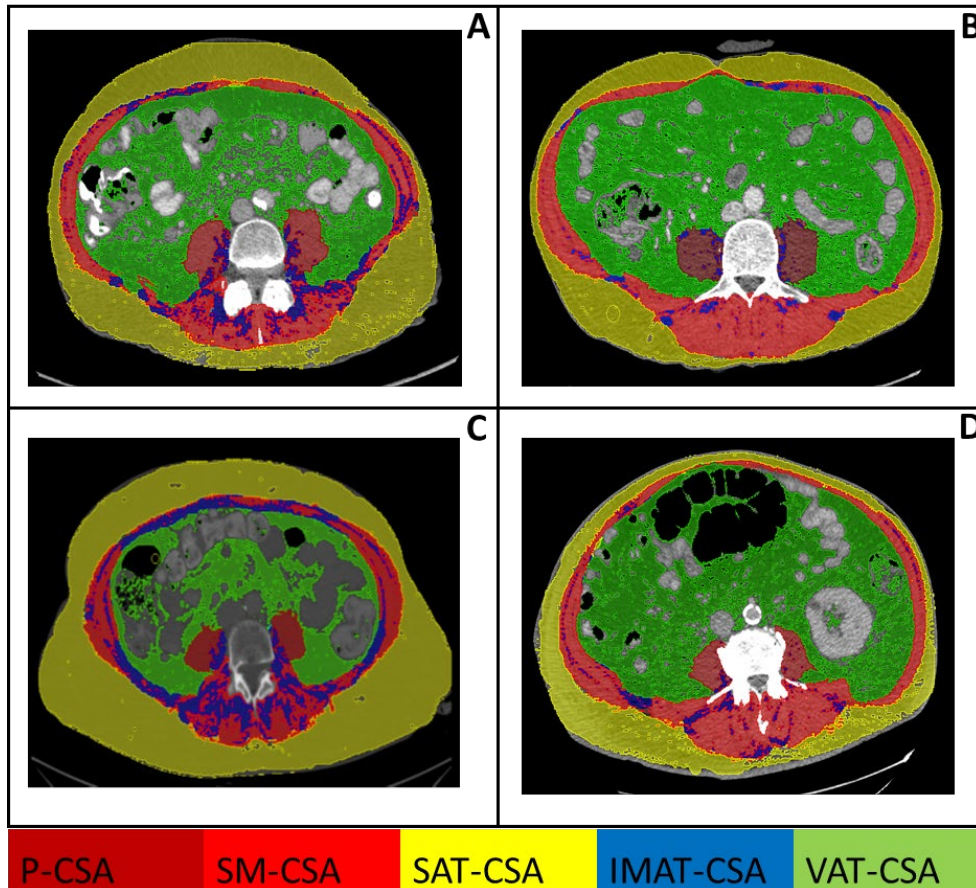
Skeletal muscle segmentation from computed tomography scan.
